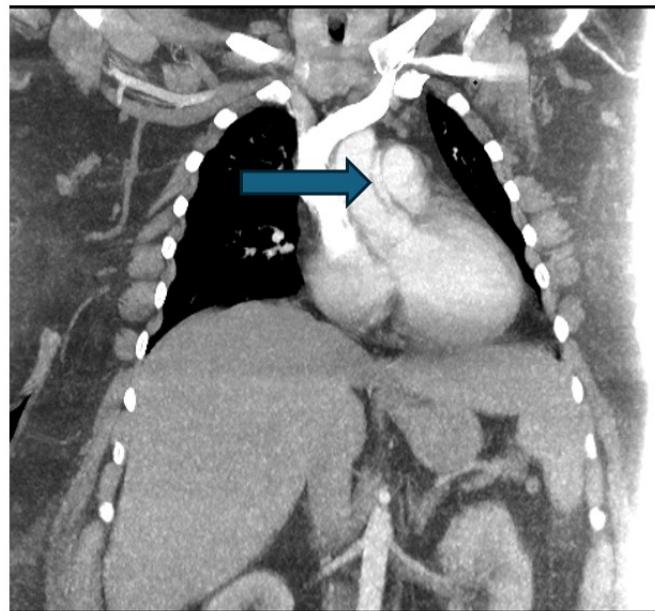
Contrast CT images in coronal plane suggestive of a type-A aortic dissection false lumen flap (blue arrow).
